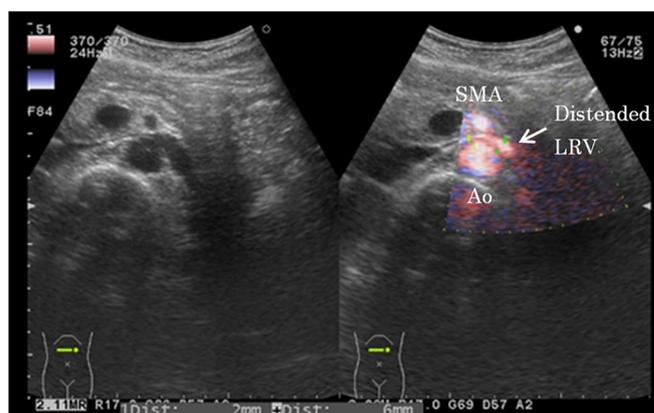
Ultrasonography revealing entrapment of the left renal vein (LRV) between the abdominal aorta (Ao) and superior mesenteric artery (SMA).
